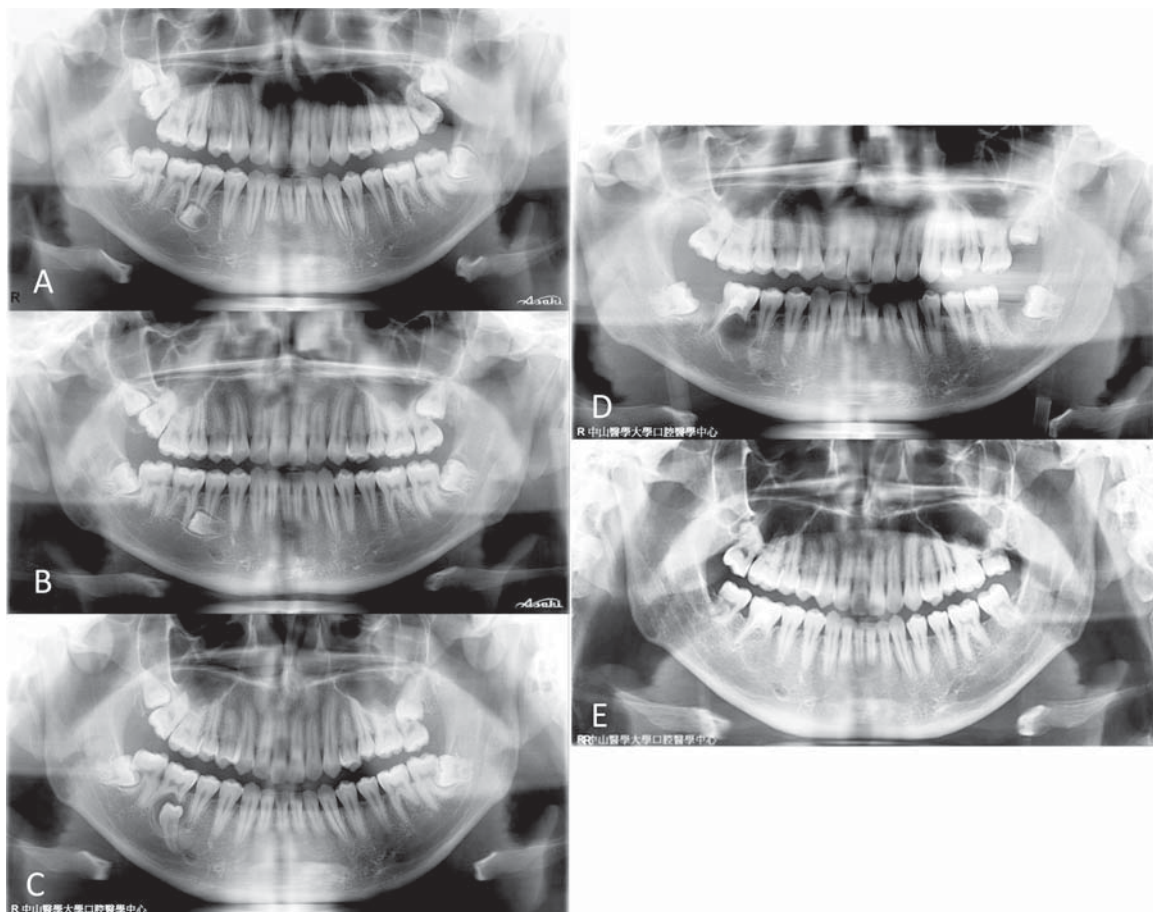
This panoramic radiography image was obtained when the patient was 13 (A), 16 (B), and 20 (C) years old. Four wisdom tooth crowns and the supernumerary tooth at the right mandible were formed at the beginning. The root resorption of teeth 27, 37, 46, and 47 was gradually appeared. After the tooth extraction (D), the patient was started on orthodontic treatment. Final image shows stable occlusion after two years of orthodontic treatment (E).
